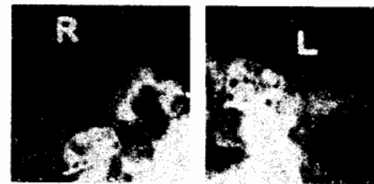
Above: Postoperative radiographs of right and left mandibular joints with prostheses in place. Maximum opening is  $\frac{3}{4}$  inch. Below: Lateral radiograph made after coronoidectomies were performed shows the maximum opening of  $1\frac{1}{2}$  inches.
